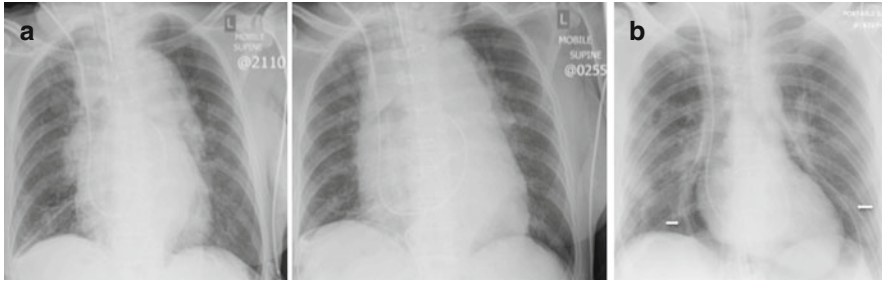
(a, b) CXR from two different patients with pericardial tamponade. (a) A 67-year old male patient who had increasing cardio-mediastinal silhouette on post surgical serial chest radiographs. (b) Another post cardiac surgery patient with pneumopericardium (*block arrows*)
